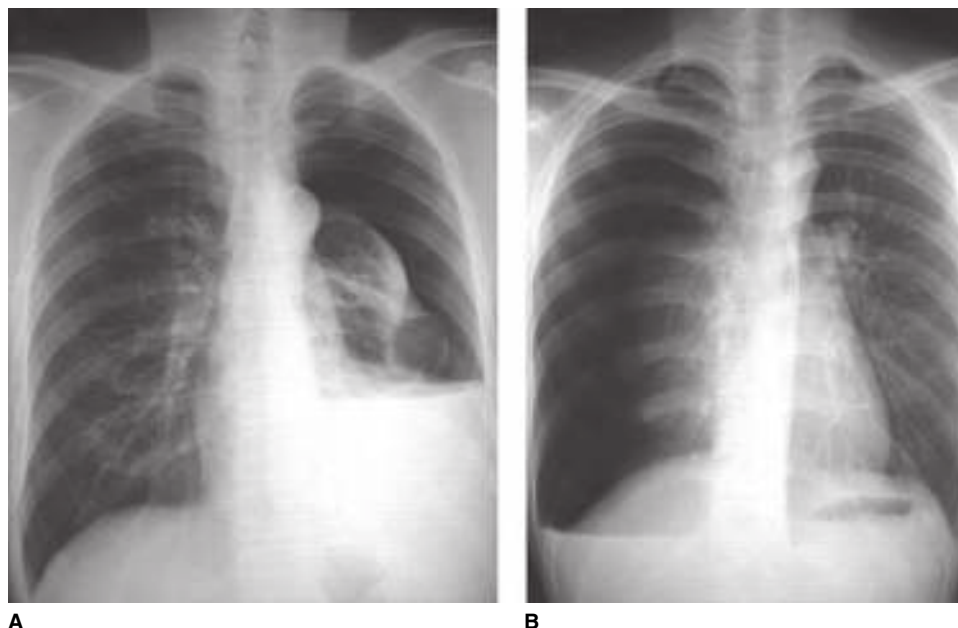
Chest radiographs. A. Left-sided pneumothorax and hemothorax. B. Right-sided pneumothorax. (Used with permission from reference 4.)
